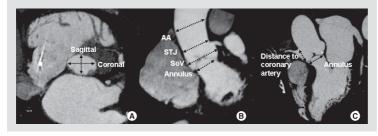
Multidetector row computed tomography assessment of the anatomy of aortic annulus and its surrounding structure. (A) Shows the cross-sectional area of the aortic annulus demonstrating the oval-shaped structure. The sagittal diameter of the aortic annulus is shorter than the coronal diameter. (B) Shows the oblique transverse view of multiplanar reformation (MPR) measuring the diameter of AA, STJ, SOV and the coronal aortic annulus diameter. The distance of SOV and coronary cusps from the aortic annulus can be derived. (C) Shows the sagittal view of MPR measuring the sagittal diameter of the aortic annulus resembling measurement from echocardiography and distance to the right coronary artery from aortic annulus. AA: Ascending aorta; SOV: Sinus of Valsalva; STJ: Sinotubular junction.
